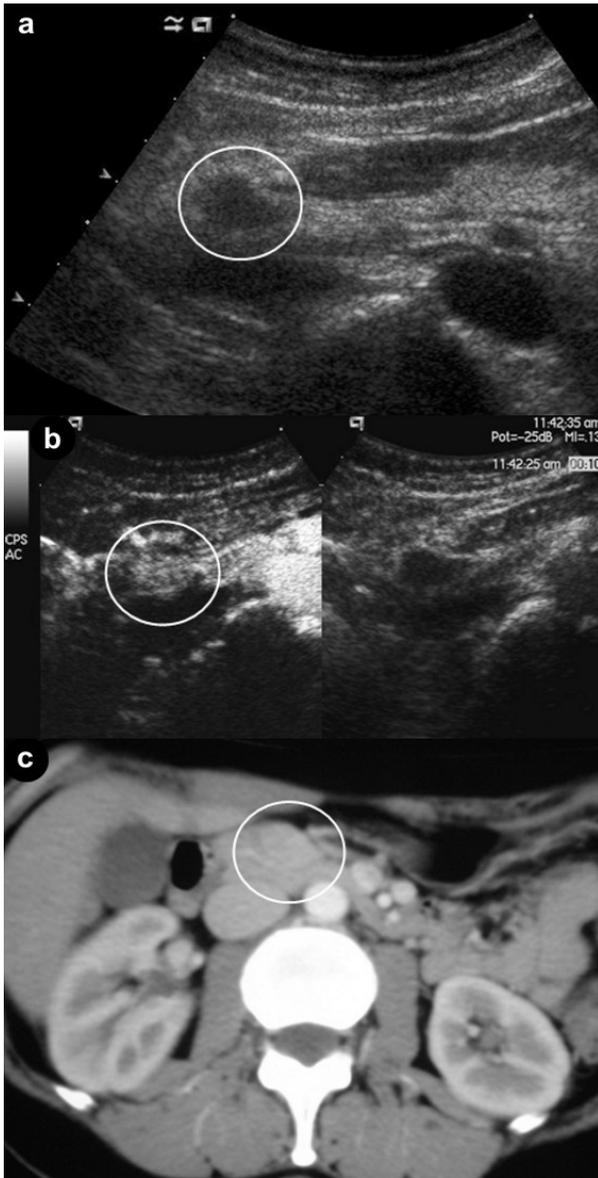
Endocrine tumor. a. US: small hypoechoic mass of the uncinus process of the pancreas (circle). b. CEUS: the mass is clearly hyperechoic (circle) during the earliest contrast-enhanced phase due to hypervascularization. c. CT: the enhancement of the lesion is less evident so that the lesion is quite isodense (circle) as compared to the rest of the pancreatic parenchyma.
